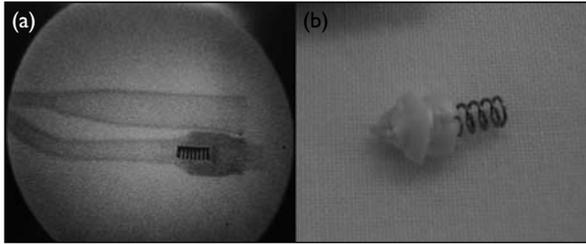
(a) X-ray screening of Foley's catheter shows a spring structure in the valve. (b) Once cut open, the spring device appears
